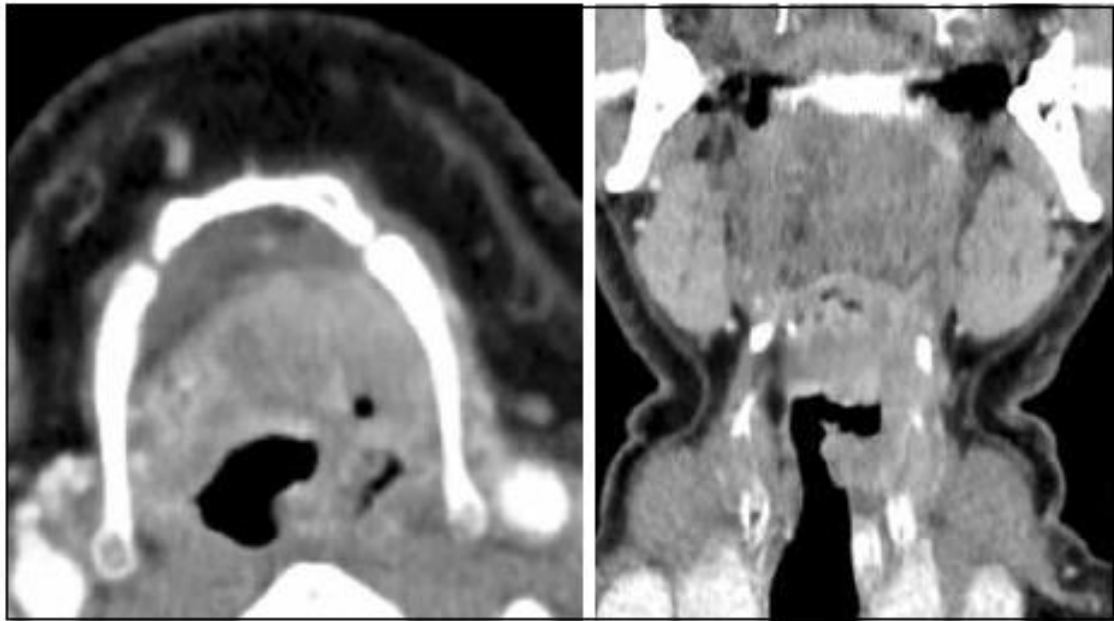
a-b) CT scan of supraglottic T4a tumors reaching the base of the tongue and involving the hyoid bone. a) Axial view. b) Coronal view.
